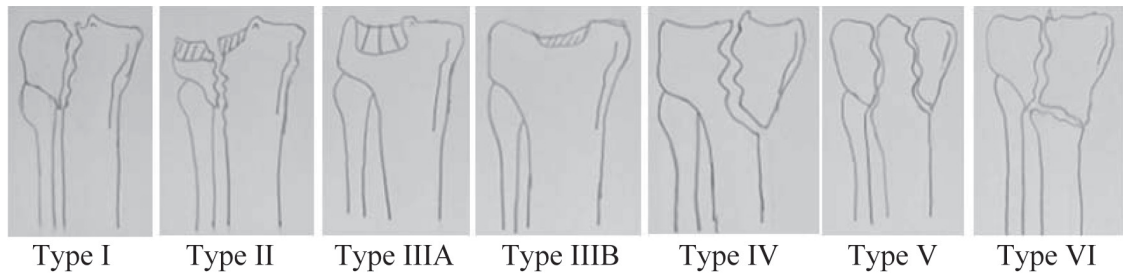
The classification according to Schatzker divides the tibial plateau fractures into six types: lateral split fracture (type I), lateral split fracture with depression (type II), central depression fracture (III), medial condyle fracture (type IV), bicondylar fracture (type V), and fracture with diaphyseal discontinuity (type VI) Adapted from Radiographics 2009;29:585-597
